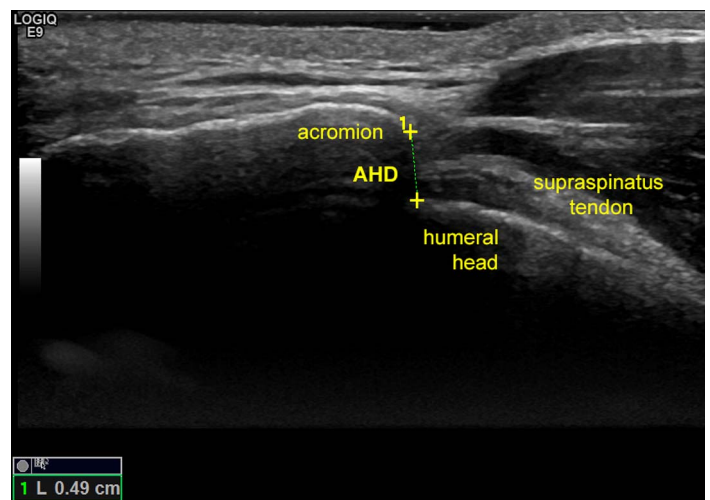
Ultrasonography of the AHD at 60° of shoulder abduction in the frontal plane. The dotted line indicates the AHD. AHD indicates acromiohumeral distance.
